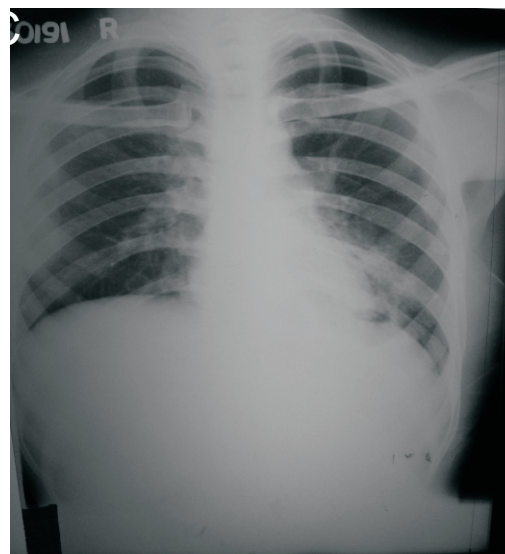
Postoperative chest radiograph after removal of the intercostal tube
